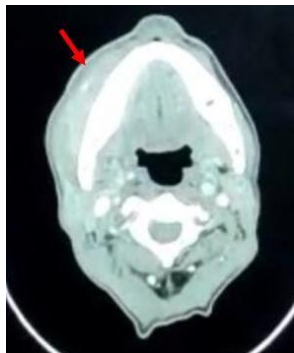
AXIAL view of the CT scan of the patient, which revealed homogeneously enhancing ill defined lesion involving the right buccal mucosa .
